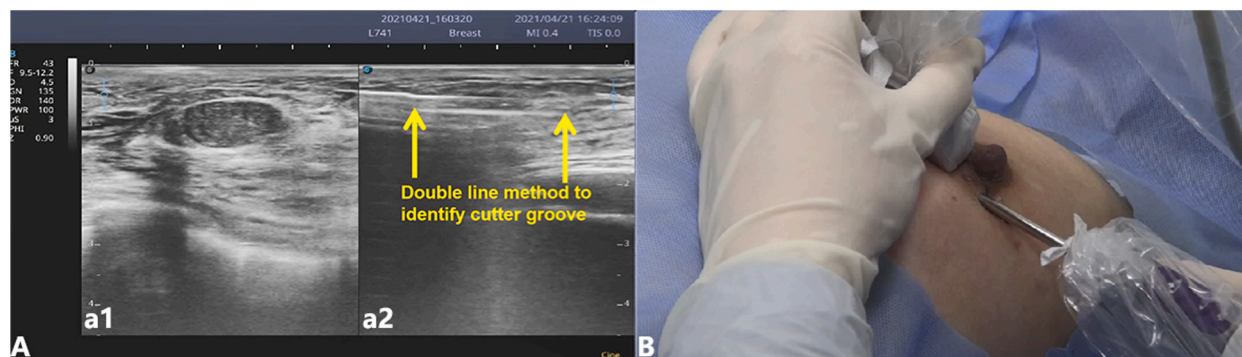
A dual-screen display and dual-line method for knife groove recognition. a1 shows a static image of the breast mass; a2 shows a dynamic image of the surgery, where the yellow arrow indicates the position of the rotational resection knife groove. B shows the identification of the knife groove with the “double-line sign” (appearing on the ultrasound screen in the right half of the left image), which is achieved by rotating the knife groove when the ultrasonic probe is parallel to the rotational resection knife groove.
